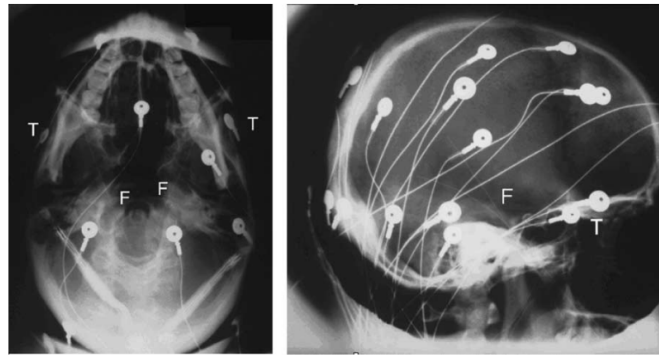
Lateral and basal X-rays showing scalp and intracranial FO electrodes. T, scalp anterior temporal electrodes; F, intracranial FO bundles.
